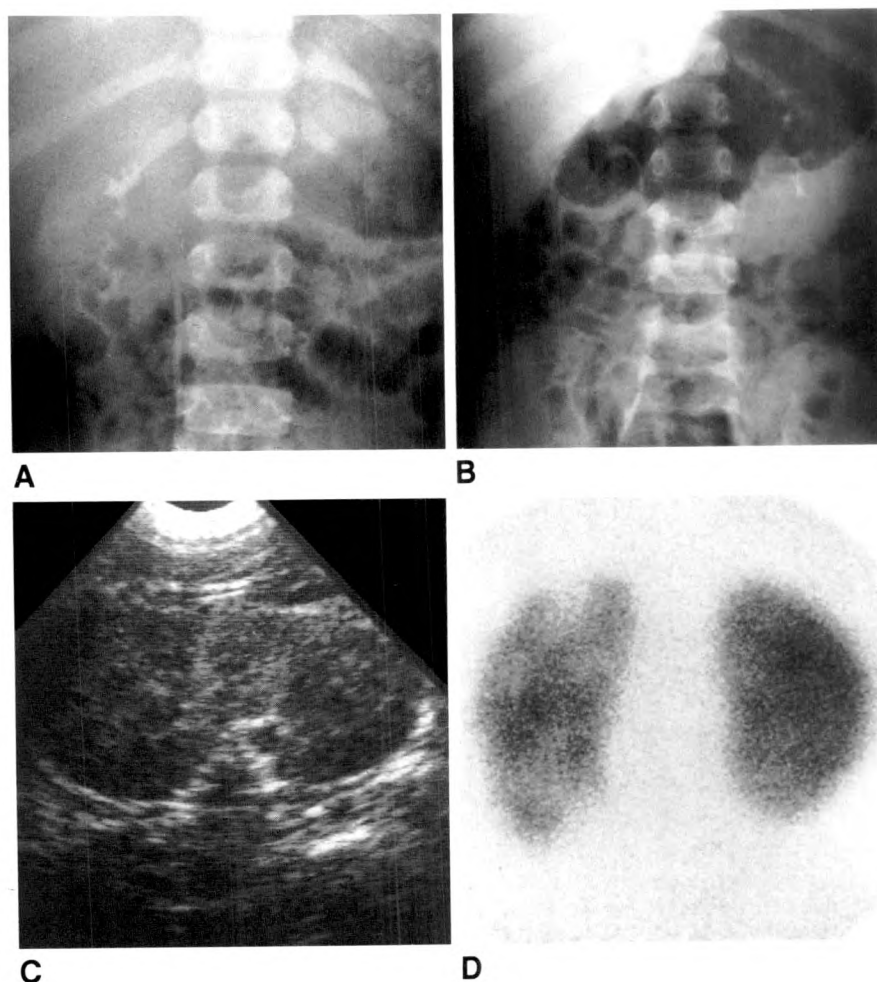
A, 2-min radiograph from excretory urogram of a 5-year-old boy with suspected upper urinary tract infection shows normal opacification of collecting system of right kidney and delayed opacification of pelvicaliceal system on left.
